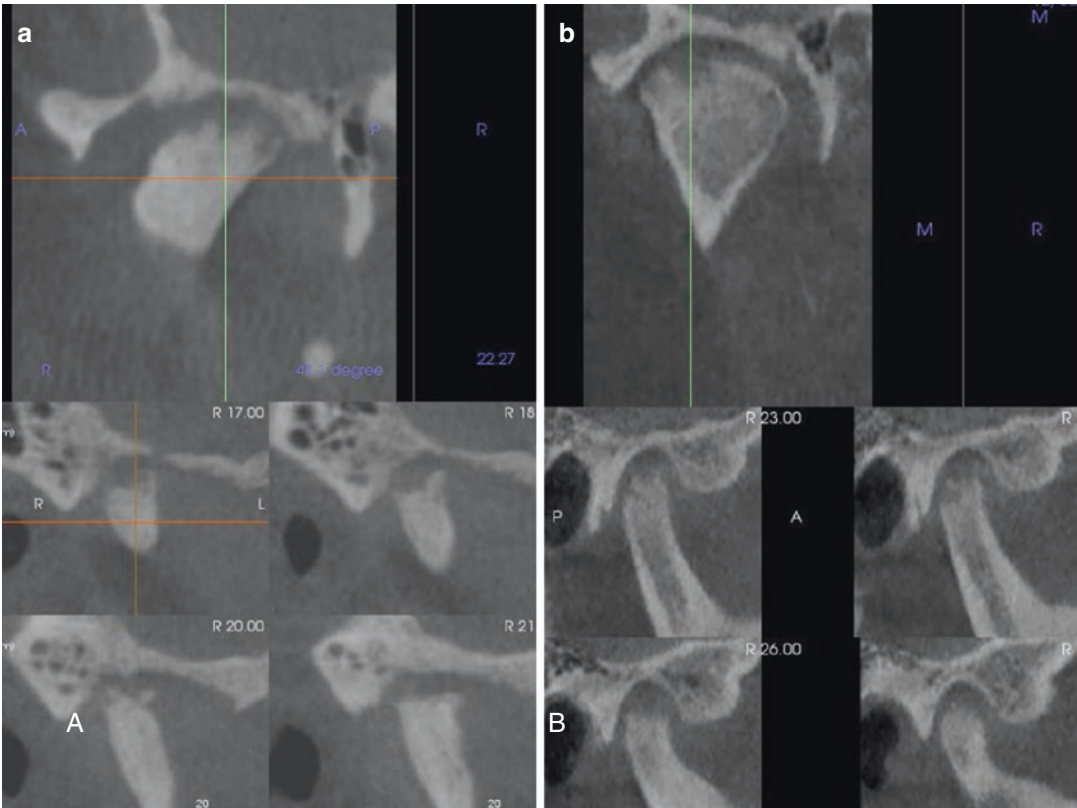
Right (a) and left (c) para-coronal reference CBCT images and right (b) and left (d) consecutive 1 mm thick parasagittal images demonstrating bilateral severe TMJ OA. Imaging features include loss of interarticular space, condylar flattening, osteophyte formation and loss of depth and sclerosis of the glenoid fossa
